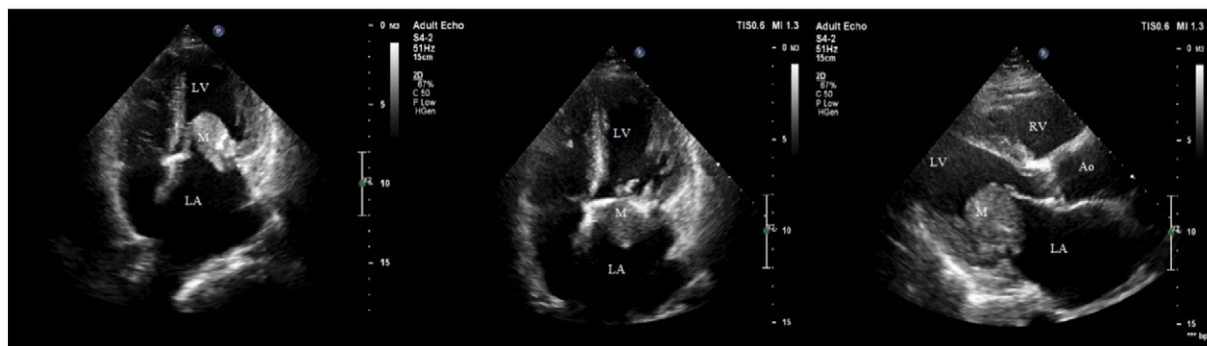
Echocardiographic views of the myxoma.
